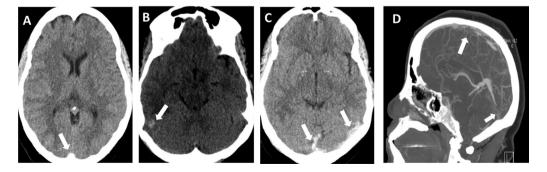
Unenhanced (A, B, C) axial cuts computed tomography (CT) scan images showing the hyperdense superior sagittal (A), right transverse (B) and the straight and left transverse sinuses (C) and CTV venography (D) showing a lack of opacification in the superior sagittal and straight sinuses.
